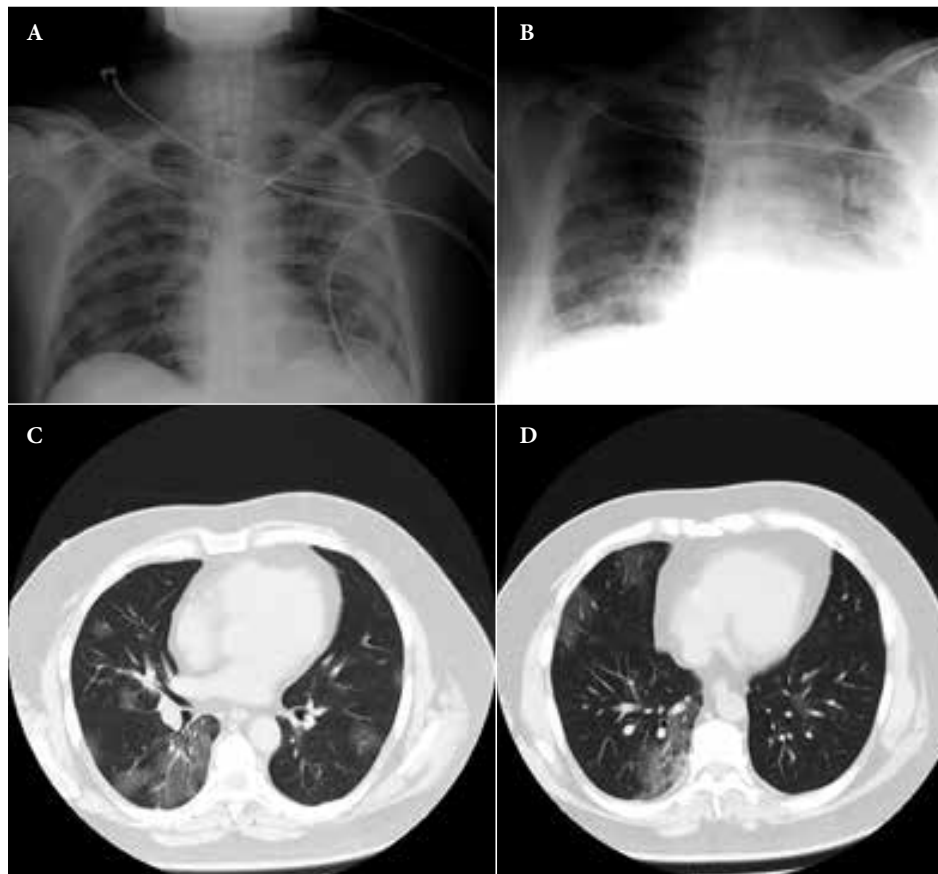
Patients with severe SARS-CoV-2 pneumonia. (A) Chest X-ray of a 25-year-old male with bilateral reticulonodular pattern. (B) Chest X-ray of a 47-year-old male with alveolar pattern and bilateral air bronchogram. (C & D) Chest CT scan images of a 53-year-old male with bilateral multilobular ground-glass focal lesions
